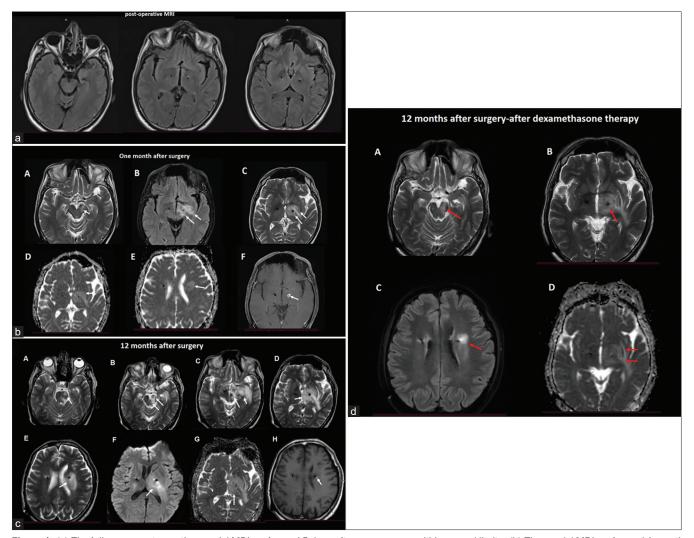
(a) The follow-up postoperative cranial MRI performed 5 days after surgery was within normal limits. (b) The cranial MRI performed 1 month after surgery due to complaints of blurry vision showed left peri-lead vasogenic edema involving the left cerebral peduncle, thalamus, and corona radiata (A–C: T2-weighted images, C–E: Apparent diffusion coefficient maps, F: post-contrast T1-weighted image). (c) The cranial MRI performed 12 months after surgery showed progression in the left peri-lead edema surrounding the left medulla oblongata and basal ganglia (A–E: T2-weighted images, F: Diffusion-weighted image, G: Apparent diffusion coefficient map, H: post-contrast T1-weighted image). (d) The follow-up MRI performed 2 weeks later showed significant resolution of the peri-lead edema (A–C: T2 weighted images, D: Apparent diffusion coefficient map)
